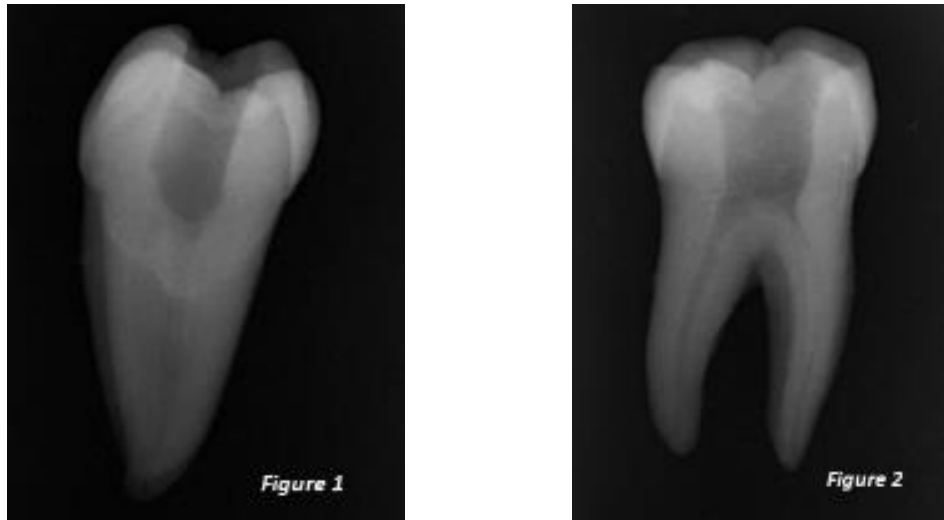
Radiographic images of initial root canals
